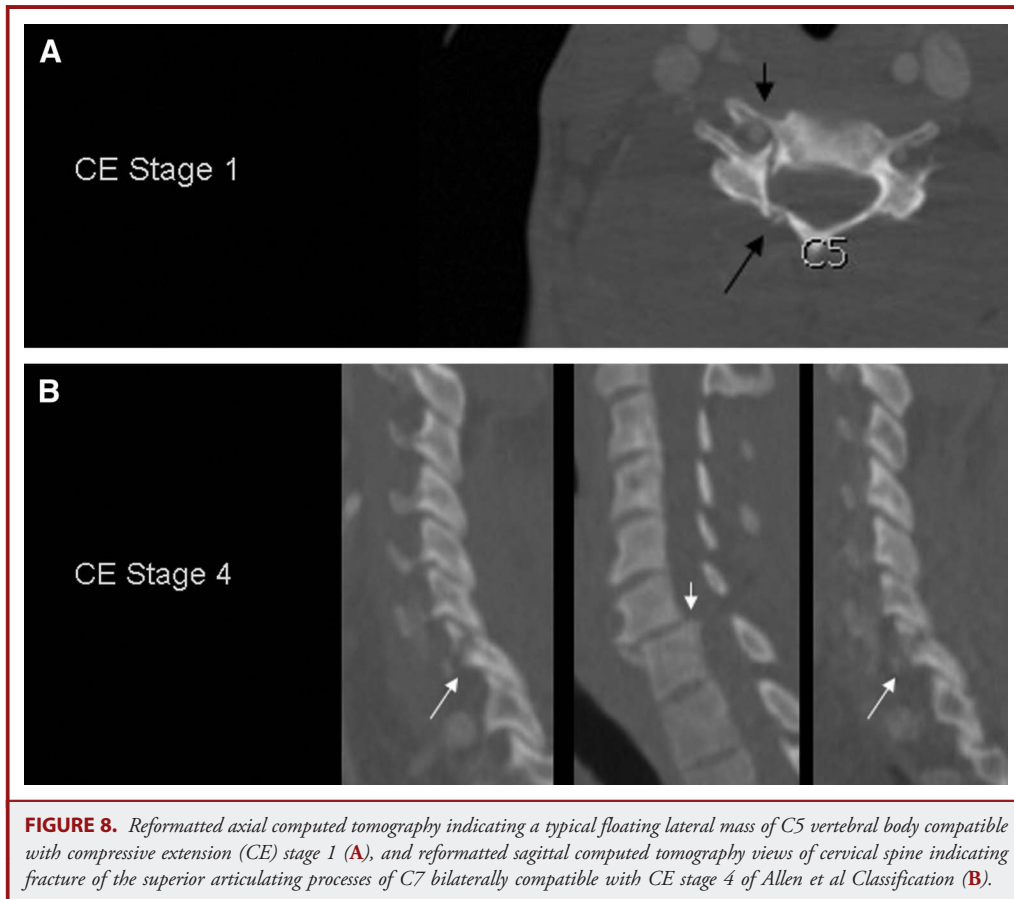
Reformatted axial computed tomography indicating a typical floating lateral mass of C5 vertebral body compatible with compressive extension (CE) stage 1 (A), and reformatted sagittal computed tomography views of cervical spine indicating fracture of the superior articulating processes of C7 bilaterally compatible with CE stage 4 of Allen et al Classification (B).
